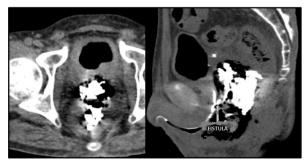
Axial and reconstructed sagittal CT scan post RGU showing fistulous communication of prostatic urethra with destructed prostate and rectum
